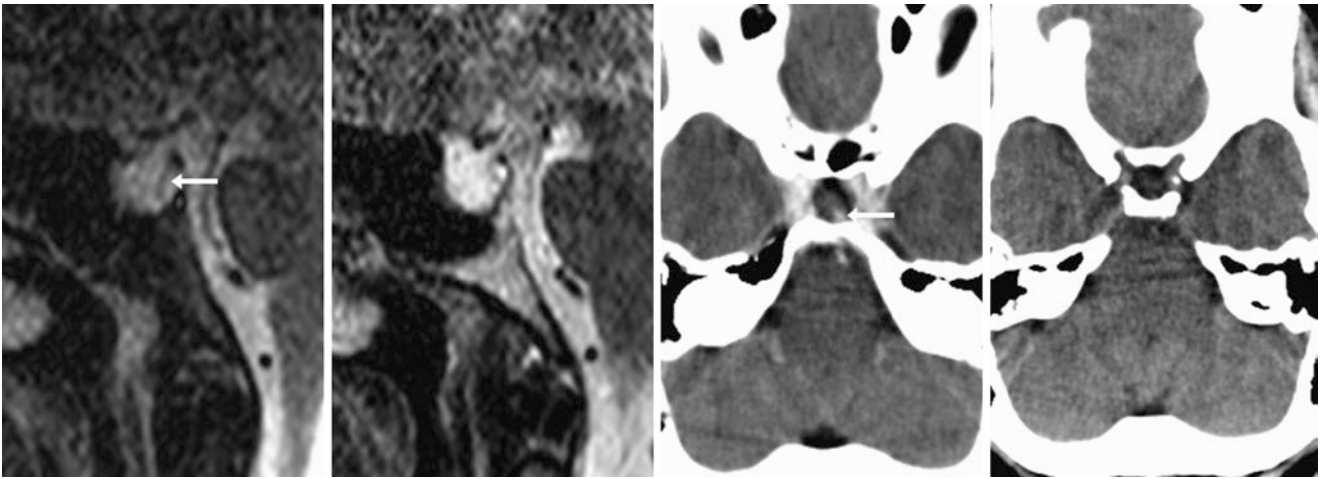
A 53-year-old asymptomatic female had an incidental complete form of PES (*) on a 1.5 T MRI sagittal STIR (*left*) and T2WI (*left middle*). This was confirmed on CECT axial reformats (*right middle*
